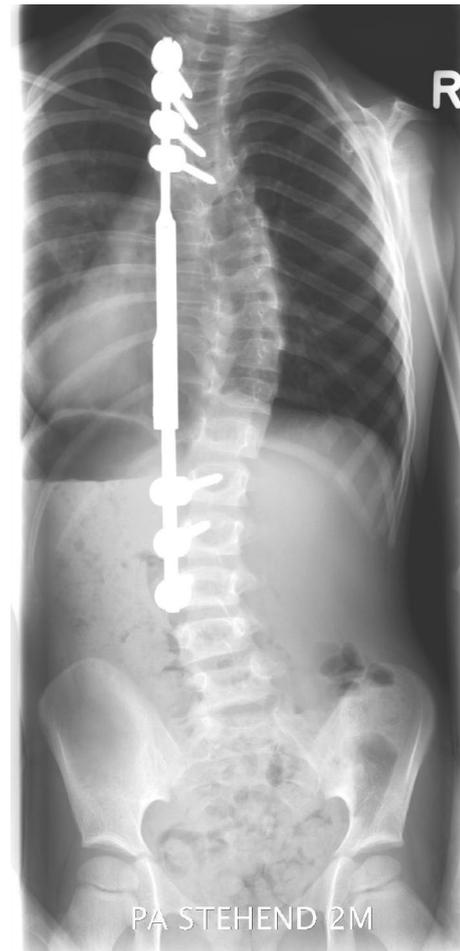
Post-index surgery Cobb angle frontal. First postoperative frontal radiograph of the spine after ratchet rod implantation. Patient no. 10, 3 years old
